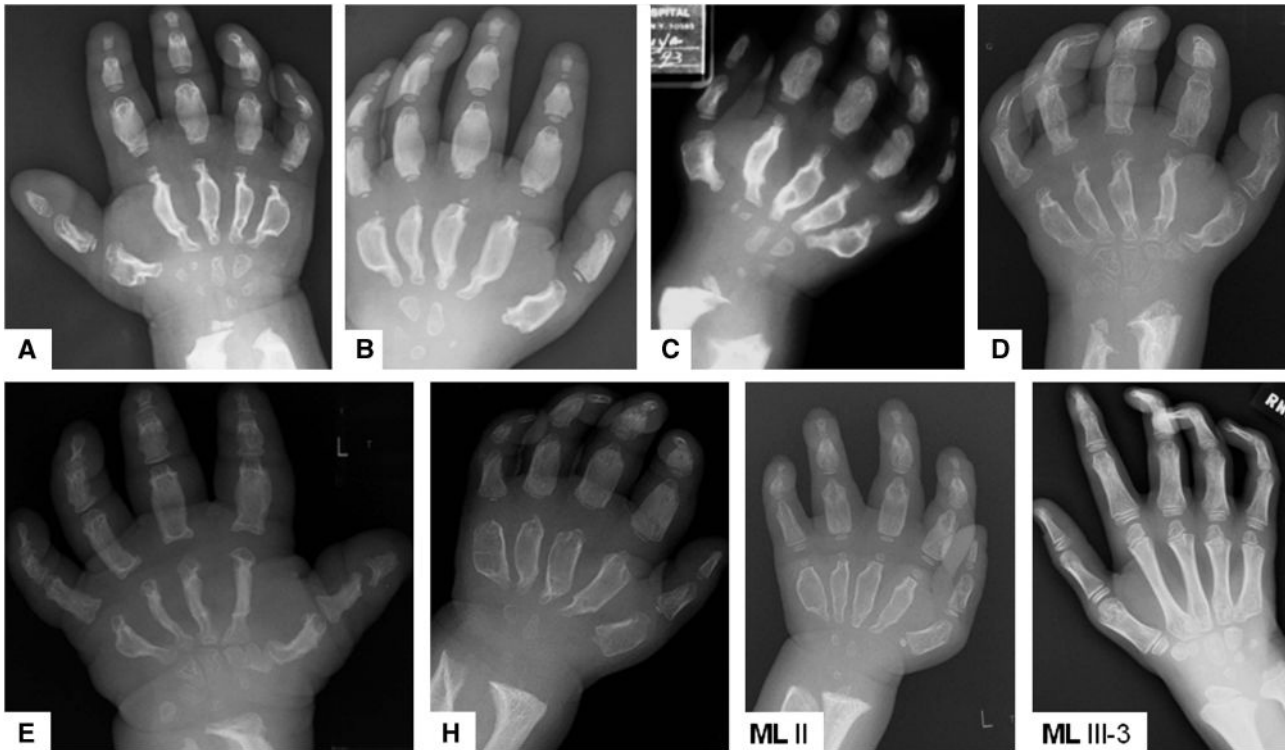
Hand radiographs in *GNPTAB* c.10A>C/p.K4Q ML patients: comparison with ML II and ML III $\alpha\beta$. DM in the hands is similar to that in ML II and distinctly more severe than in ML III $\alpha\beta$. Figures show shortening and diaphyseal widening in all tubular hand bones; severely delayed and deficient ossification of epiphyses, carpal bones and the distal ulnar and radial epiphyses; and apparent regression of mid-diaphyseal widening in older patients concomitant with progressive generalized osteopenia. A: Patient 1 at 8 years; B: Patient 2 at 4 years; C: Patient 3 at 9 years; D: Patient 4 at 9 years; E: Patient 5 at 19 years; H: Patient 8 at 6 years; ML II: female with ML II at 4 years; ML III-2: female with ML III $\alpha\beta$ at 13 years.
